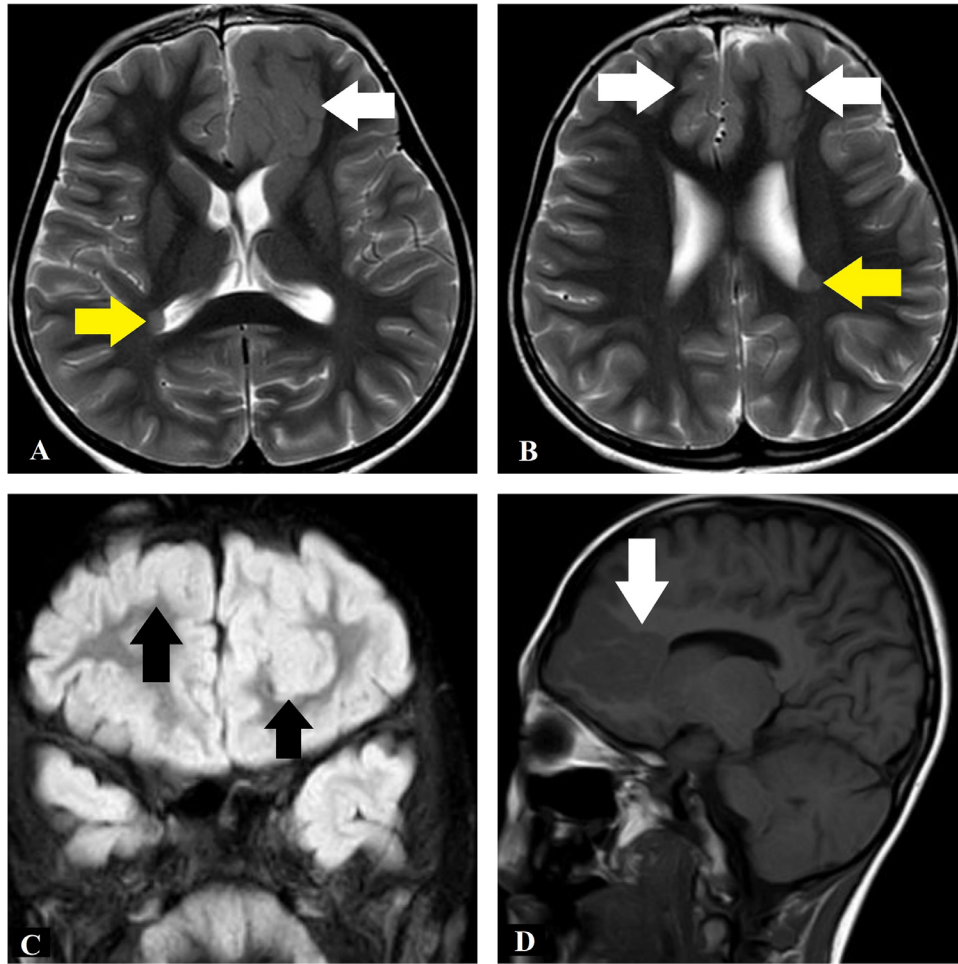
(A) T2 axial image at thalami level shows a T2 hypointense lesion in the left frontal lobe extending to the frontal horn (white arrow) and a nodular lesion in the right ventricle atrium (yellow arrow). (B) T2 axial image at the parietal level shows mild cortical thickening in both frontal lobes (white arrows) and a left periventricular nodular lesion (yellow arrow). (C) Fluid attenuation inversion recovery (FLAIR) coronal image shows a lesion with signal intensity similar to the cerebral cortex in left frontal white matter with cortical thickening in both frontal lobes (black arrows). (D) Sagittal image shows a well-defined cortical-like lesion in the left frontal lobe extending to the frontal horn. Diagnosis of grey matter heterotopia in left frontal lobe, focal cortical dysplasia in bilateral frontal lobes and bilateral subependymal heterotopia was made.
